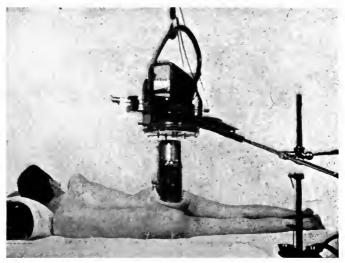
The technic of a lateral roentgenogram of the left hip. (Method of Lilienfeld.)
